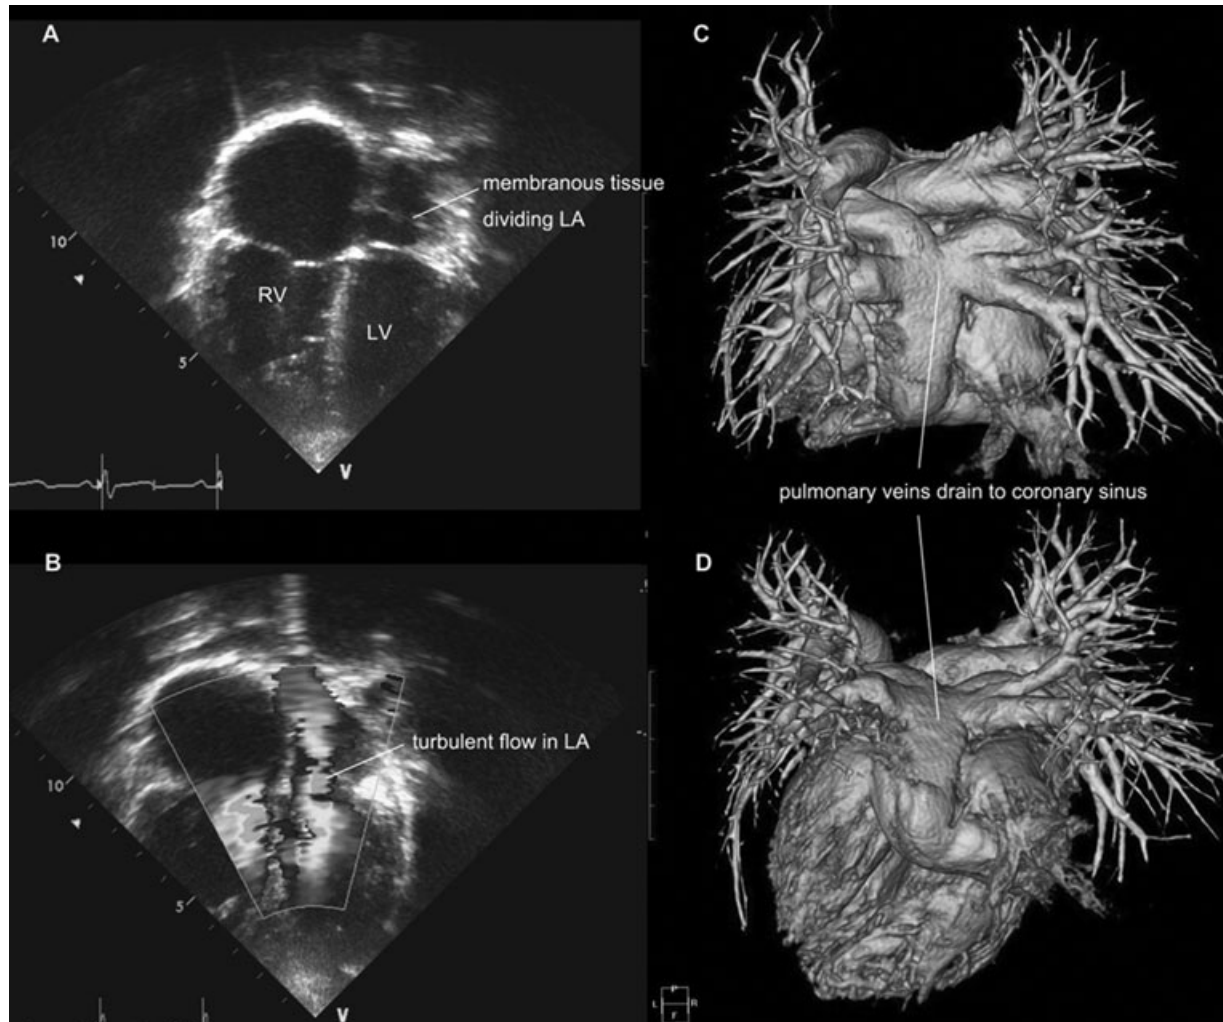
Preoperative diagnostic findings. Panels A and B are echocardiography images showing membranous tissue in the left atrium mimicking cor triatriatum. Panels C and D are CT 3D images showing all pulmonary veins connected to the enlarged coronary sinus. LA = left atrium; LV = left ventricle; RV = right ventricle.
